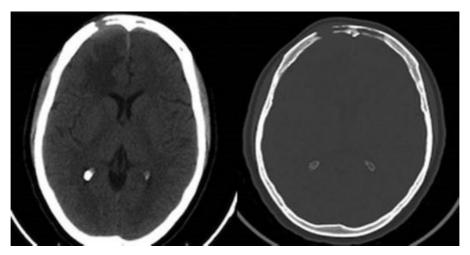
A Skull CT (axial cut) shows a lytic lesion in the right frontal region and loss of cortical-subcortical differentiation.
